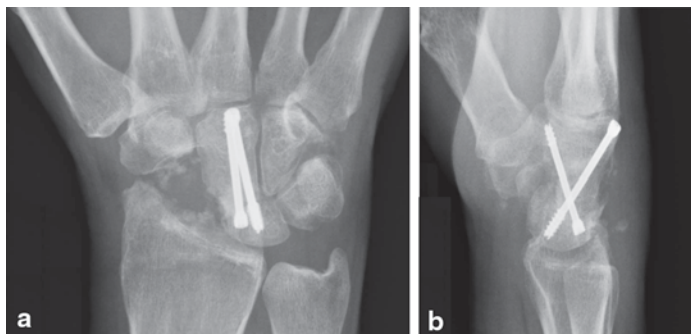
a PA X-ray showing healing of the CL fusion without hardware migration. b Lateral X-ray showing healing of the CL fusion without hardware migration. (Published with kind permission of ©R. Glenn Gaston, 2015. All Rights Reserved)
